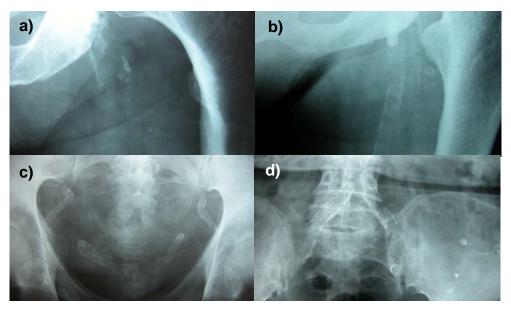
Intima and media calcification by radiography. a) Femoral artery intimal calcification; b) Femoral artery medial calcification; c) Pelvic artery medial calcification; d) Iliac arteries mixed calcification. (London et al. 2003).
